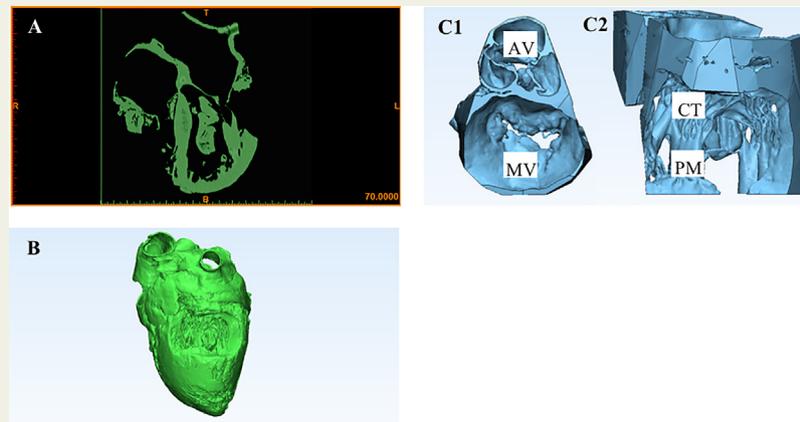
Prototype method for 3D modelling of the MV. CT scans of a plastinated human heart were segmented (A) and a virtual 3D model was calculated (B). The model was then trimmed to isolate the MV apparatus and aortic valve (C). Abbreviations: AV, aortic valve; CT, chordae tendineae; MV, mitral valve; PM, papillary muscle.
